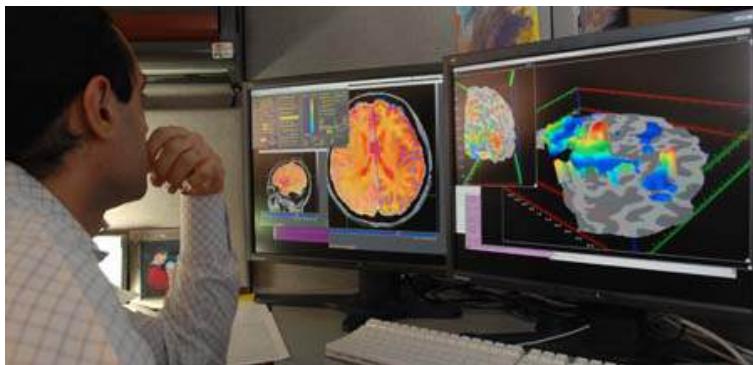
Researcher checking MRI images. On the monitor on the right, activations are overlaid on brain structure; typically "hotter" colors (reds and oranges) denote *more* brain activation than a baseline, and "cooler" colors (blues and greens) denote *less* brain activation than baseline.
